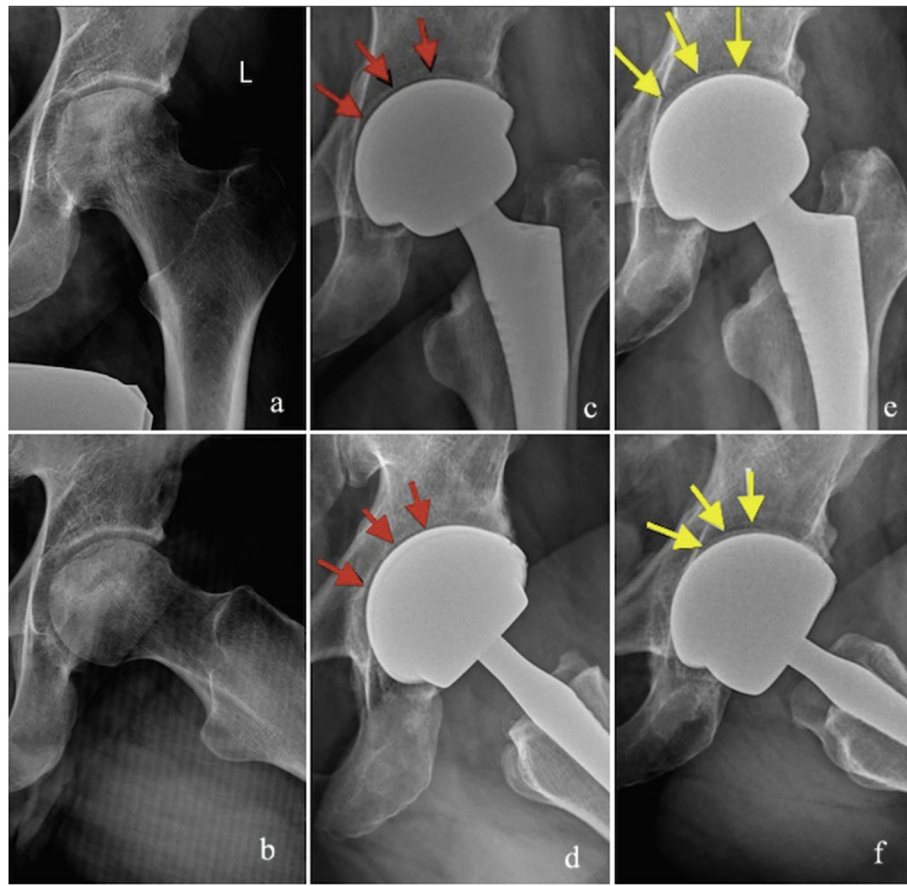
Radiographic images of a representative patient (a) pre-operative AP view (b) pre-operative frog leg lateral view (c) immediate post-operative AP view (red arrows showing dome gap) (d) immediate post-operative frog leg lateral view (red arrows showing dome gap) (e) Nine month post-operative AP view (yellow arrows showing bony ingrowth into the gaps) (f) Nine month post-operative frog leg lateral view (yellow arrows showing bony ingrowth into the gaps).
